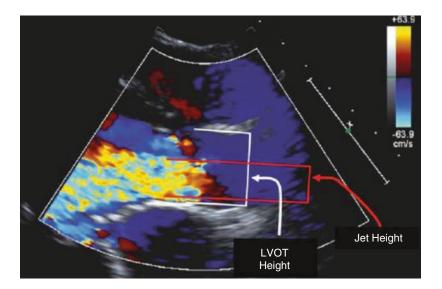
Transthoracic echocardiogram at long-axis view demonstrates color Doppler method of the ratio of jet height to LVOT height to assess the severity of aortic regurgitation
